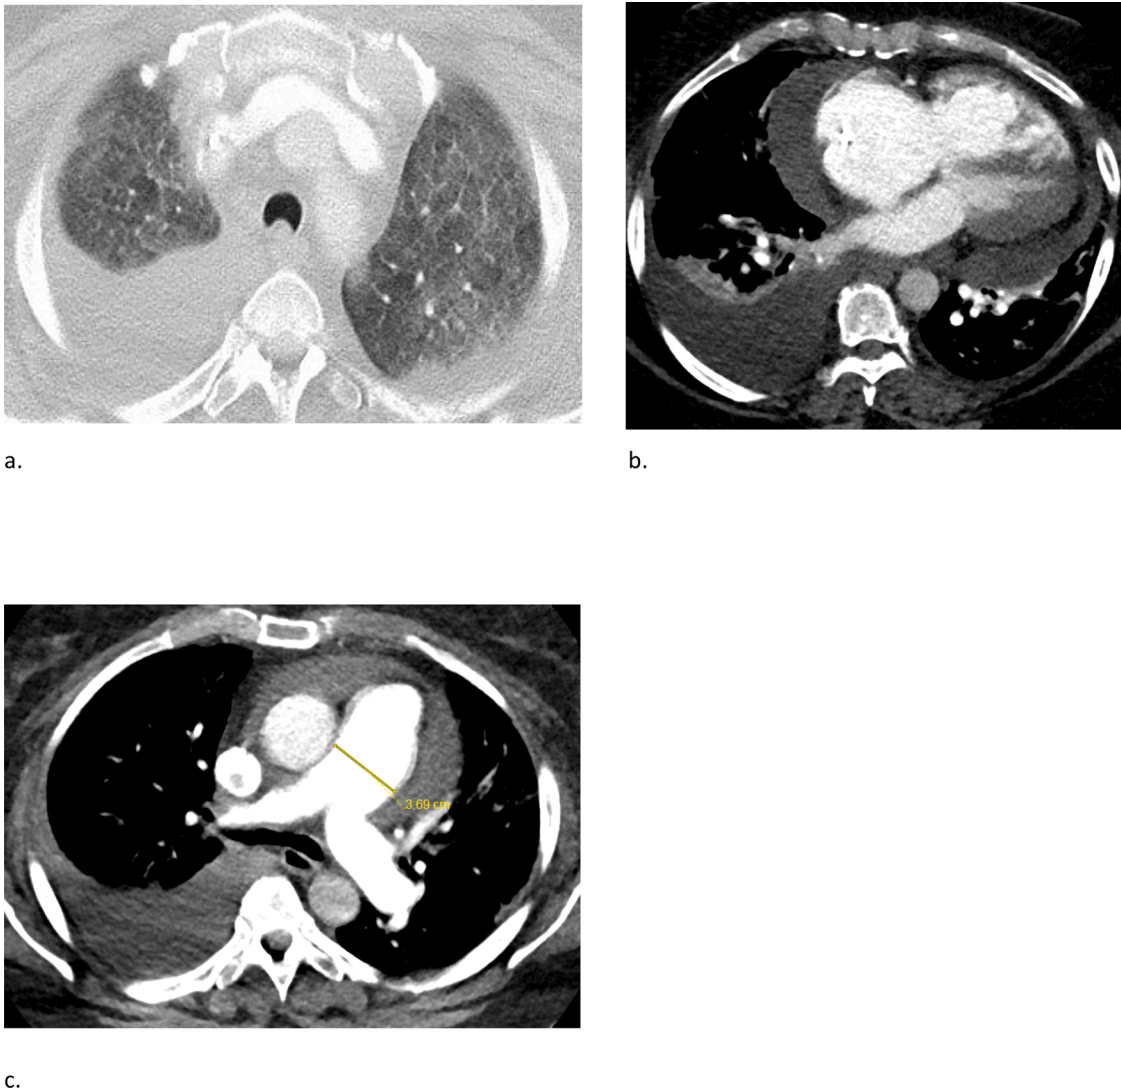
58 yo F with severe shortness of breath attributed to PVOD. (a) CT of the chest demonstrating diffuse ground-glass opacities, interlobular septal thickening, and pleural effusions. Note that the right heart (b) and main pulmonary artery (c) are enlarged. The pulmonary capillary wedge pressure (PCWP) was normal.
